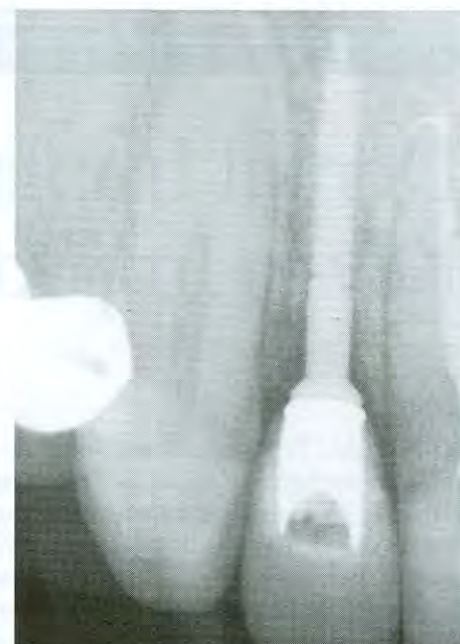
Digital periapical radiographic view upon case completion.
